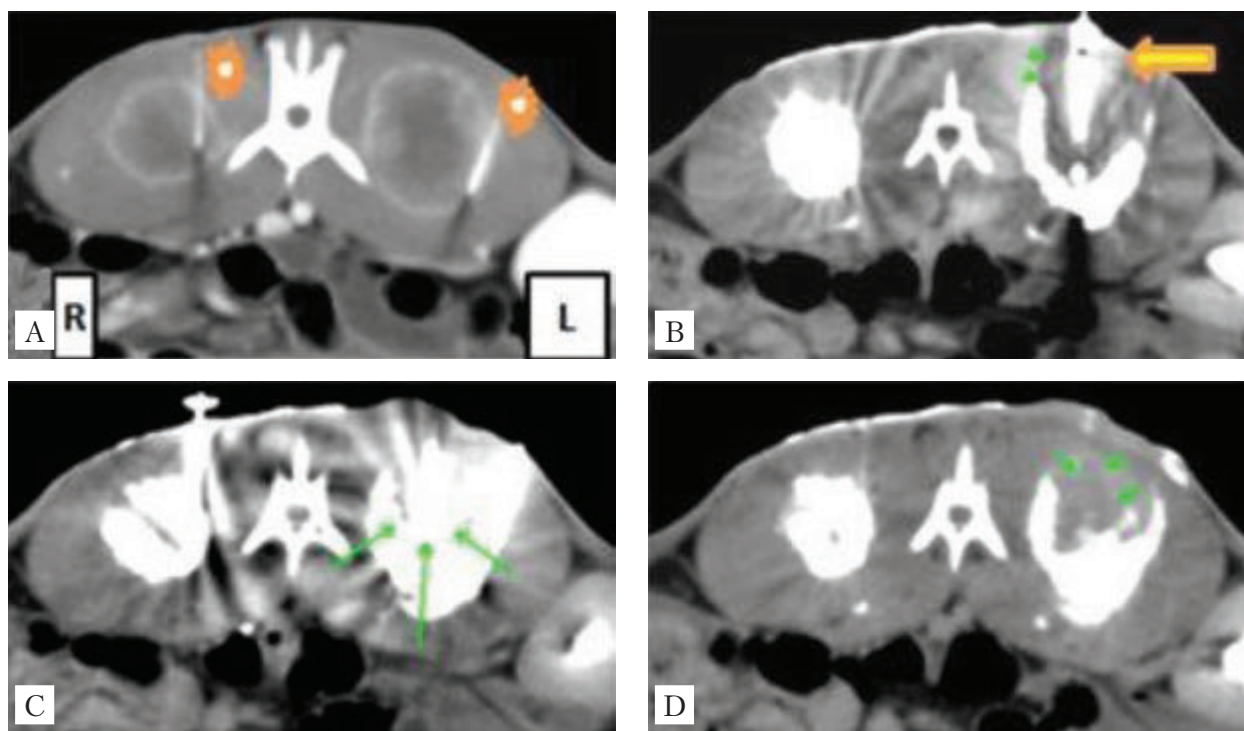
CT-guided percutaneous injection, ITCH, (R) or cryoprobe-assisted injection, CACH, (L) of therapeutic mixture in the VX2 tumor margin (adapted from ref. 30). A. CECT guided needle (asterisk) positioning along enhancing tumor rim (white arrows); B. at end of first 0.4 mL injection sequence, the TTM contrast agent tracer (ioversol) does not permeate the frozen core of the left side tumor, penetrated with cryoprobe (yellow arrow), but permeate the unfrozen tumor of right side; tracer flows along the L ice margin with an arc-like pattern. Reflux through the needle tract is minimal; C. during the thaw period following each injection, the marginal tracer penetrates the melting ice towards tumor core (green arrows); D. 20 minutes after the procedure, a larger amount of fluid and tracer, 50% of the injectate, leaks out of the left side tumor core (short green arrows) during probe and needle removal compared to the right side
